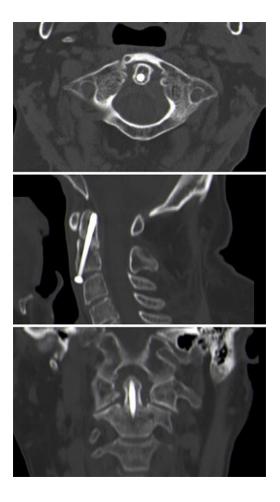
Control CT scan (7th postoperative month).
